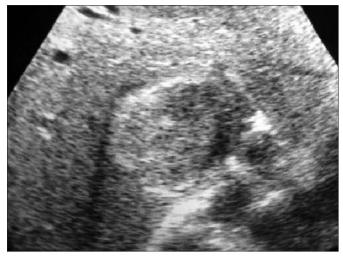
Abdominal ultrasonography examination demonstrates the heterogeneous, intraluminal soft tissue mass in the hepatic vein level dilating the inferior vena cava.
